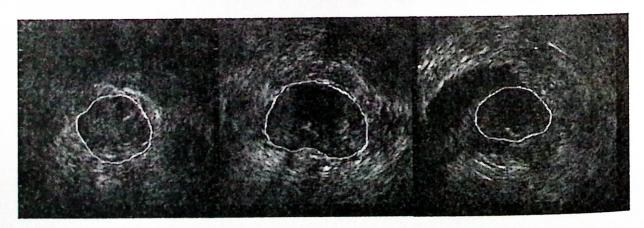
Annotated ultrasound images of the prostate
